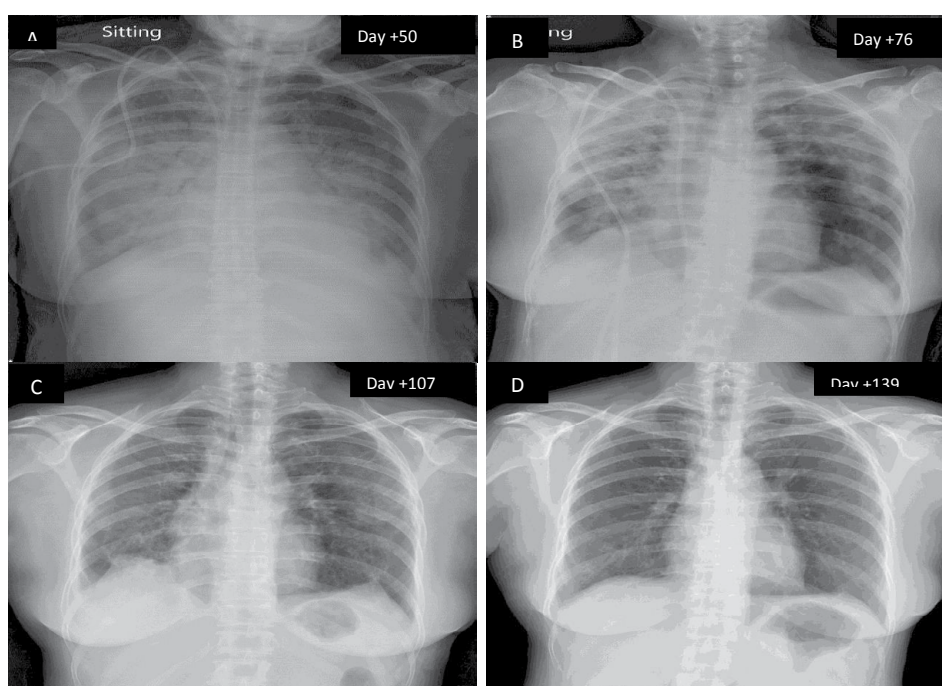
Serial chest radiographs showing progression of diffuse pulmonary infiltrates on both lung fields (A, B) and a chest radiograph showing complete resolution of infiltrates after 7 weeks of anticoagulation (C, D).
